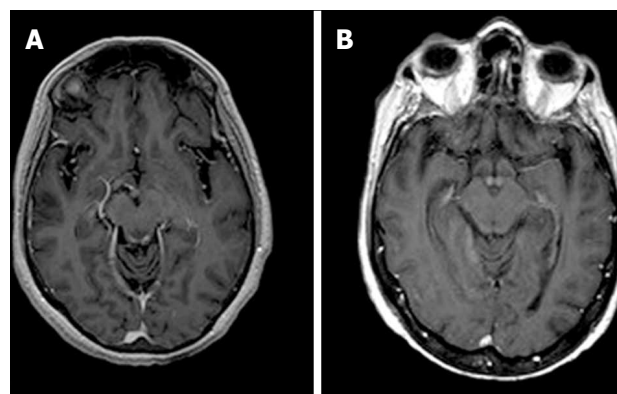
Axial T1-weighted magnetic resonance images after contrast material administration in a patient with alcoholic Wernicke's encephalopathy. A: Enhanced axial T1-weighted image shows contrast-enhancement of the periaqueductal grey matter; B: Enhanced axial T1-weighted image shows contrast-enhancement around the mammillary bodies.
